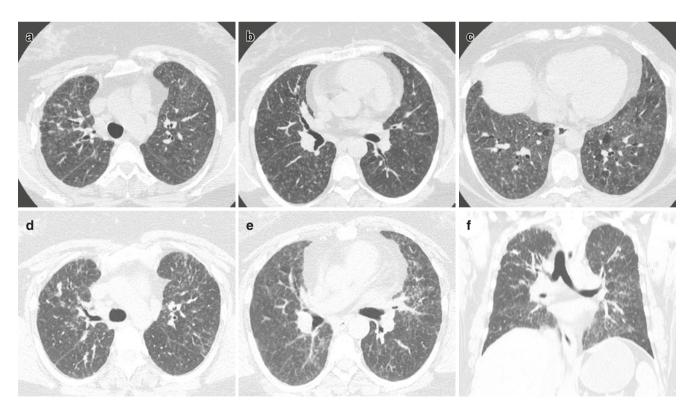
45-year-old woman, a bird owner who presented with dyspnea. (a–c) Initial axial CT images show diffuse ground-glass density centrilobular nodules, GGOs, mild bronchial dilatation, and mild
